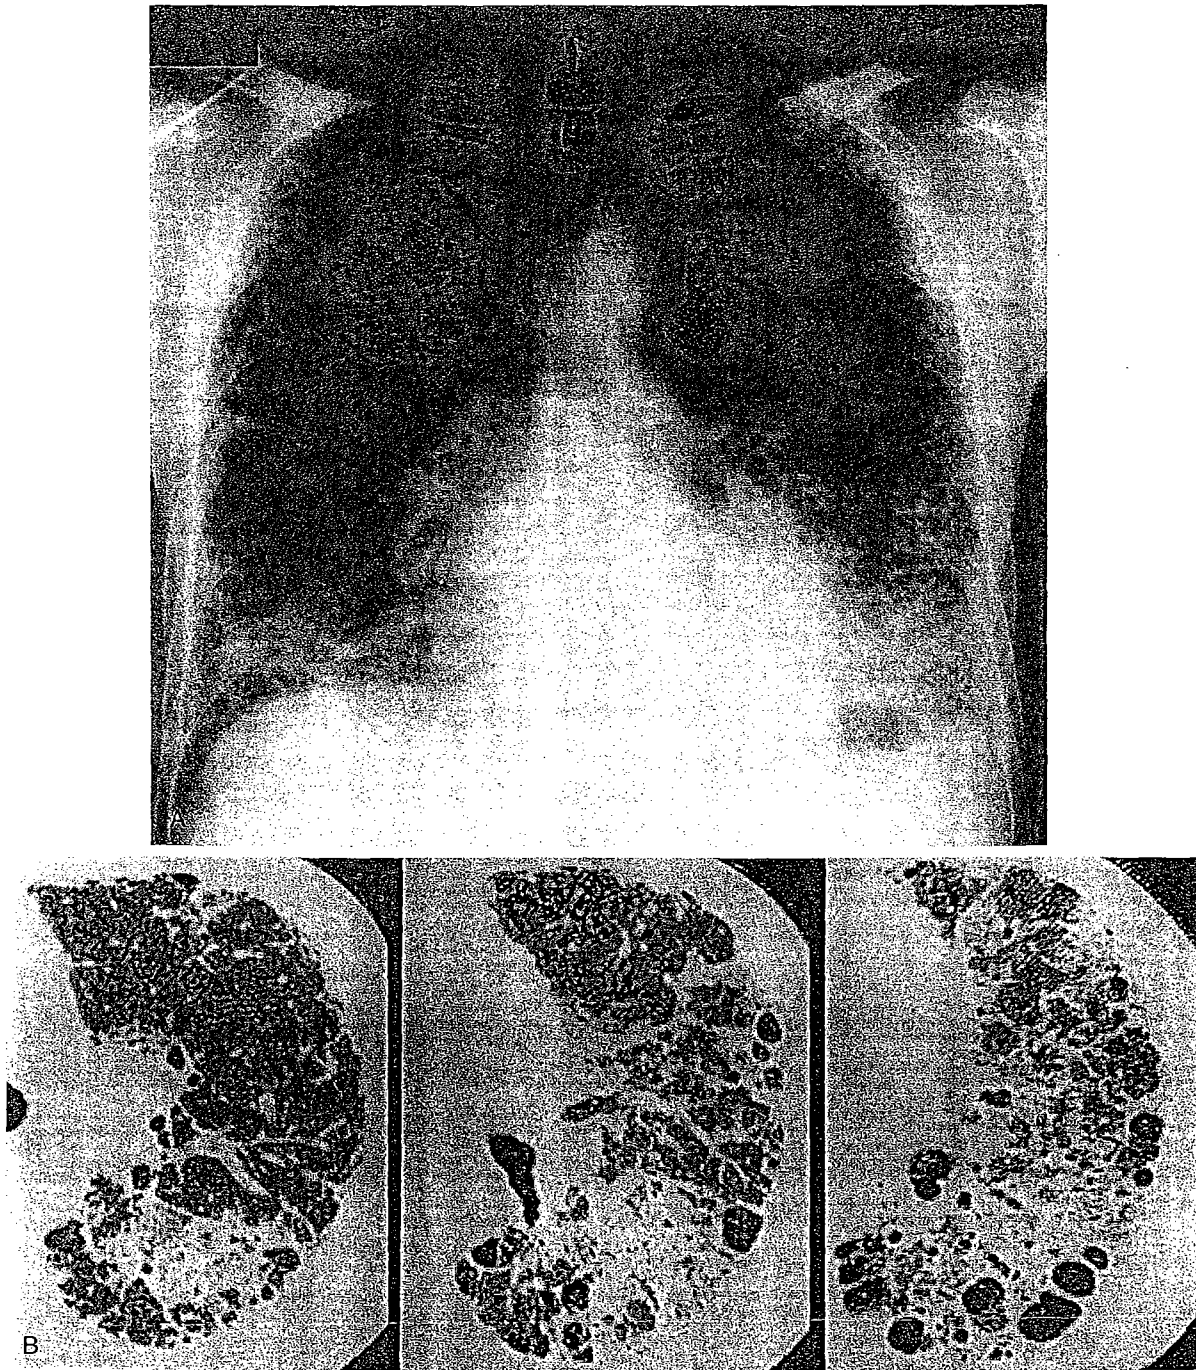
Hard Metal Lung Disease. A 45-year-old Japanese man presented with exertional dyspnea. He had a history of exposure to hard metal for 5 years. A chest radiograph (A) demonstrates a coarse reticular pattern involving mainly the peripheral lung regions and the lower lung zones. HRCT images targeted to the left lung (B) demonstrate extensive areas of ground-glass attenuation. Irregular linear opacities and traction bronchiectasis consistent with fibrosis are also evident. Several cystic spaces consistent with end-stage honeycombing are present in the subpleural lung regions. (Courtesy of Dr. Masanori Akira, Department of Radiology, National Kinki Chuo Hospital Chest Disease, Osaka, Japan.)
